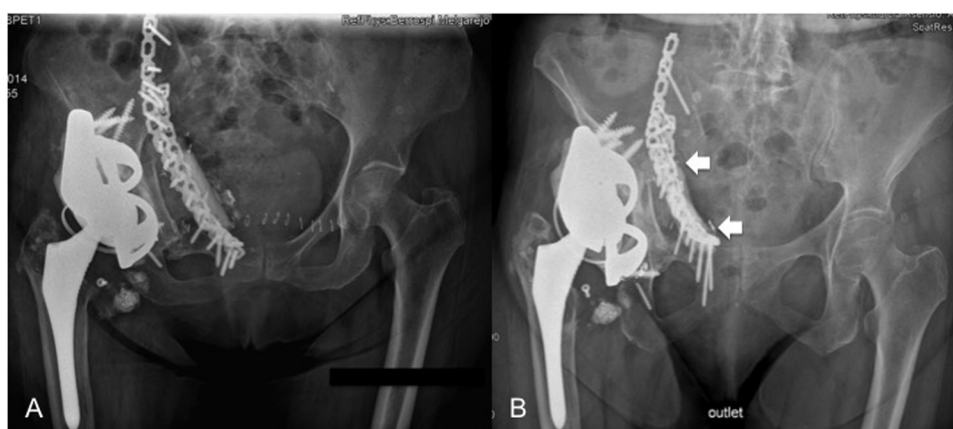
Postoperative x-ray (25 days after surgery) (A) and one-year follow-up x-ray (B) (arrows show the image of strut allograft remodelling).
